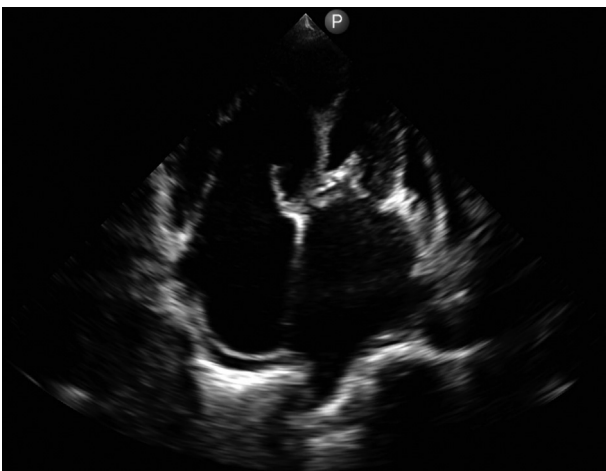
Apical four-chamber view by two-dimensional transthoracic echocardiography showing mitral leaflet calcification and thickening in diastole. There is restricted motion of the mitral leaflets compared to the tricuspid leaflets. Both atria visually appear dilated. The right ventricle appears dilated, while the left ventricular cavity appears small. There is a small pericardial effusion.
